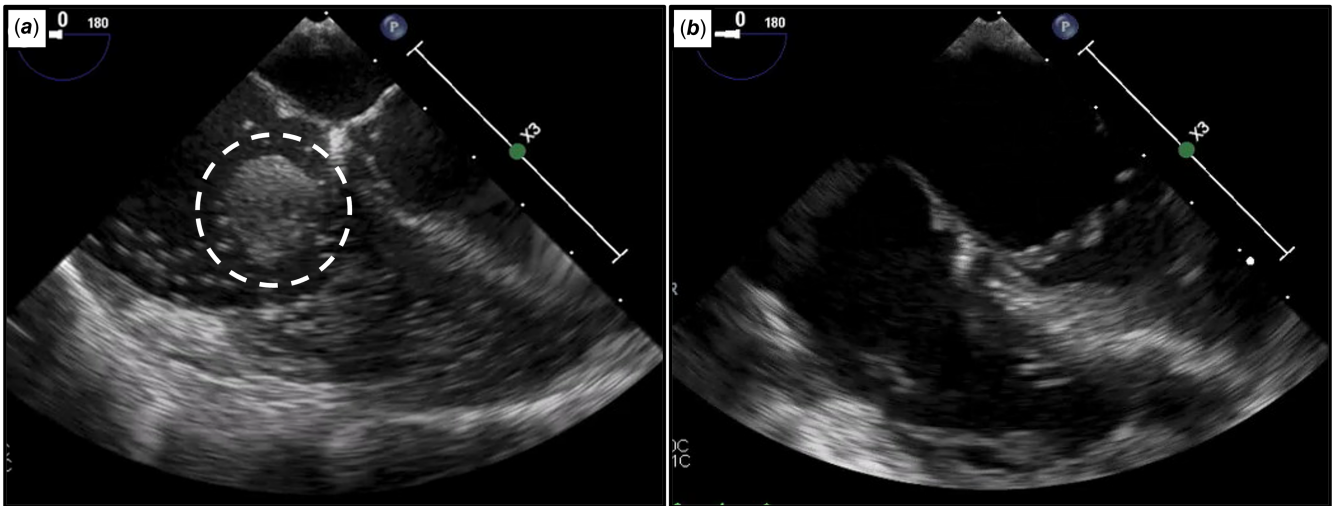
Transoesophageal ECHO mid-diastole (a) pre-operative ECHO depicting mass attached to the tricuspid valve. (b) post-operative ECHO revealing normal functioning tricuspid valve with no residual tumour.
